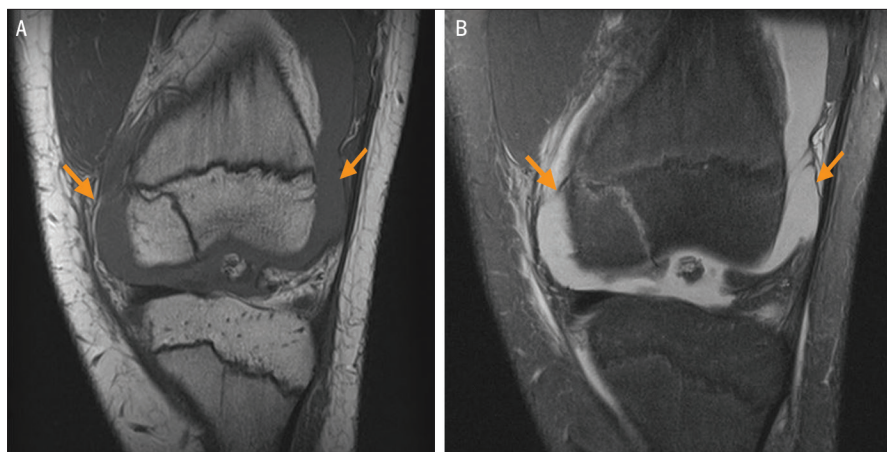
(A) T1-weighted and (B) T2-weighted magnetic resonance images coronal view showing a fracture that begins at the physis and extends to the articular surface. Hemarthrosis is present (arrows).
